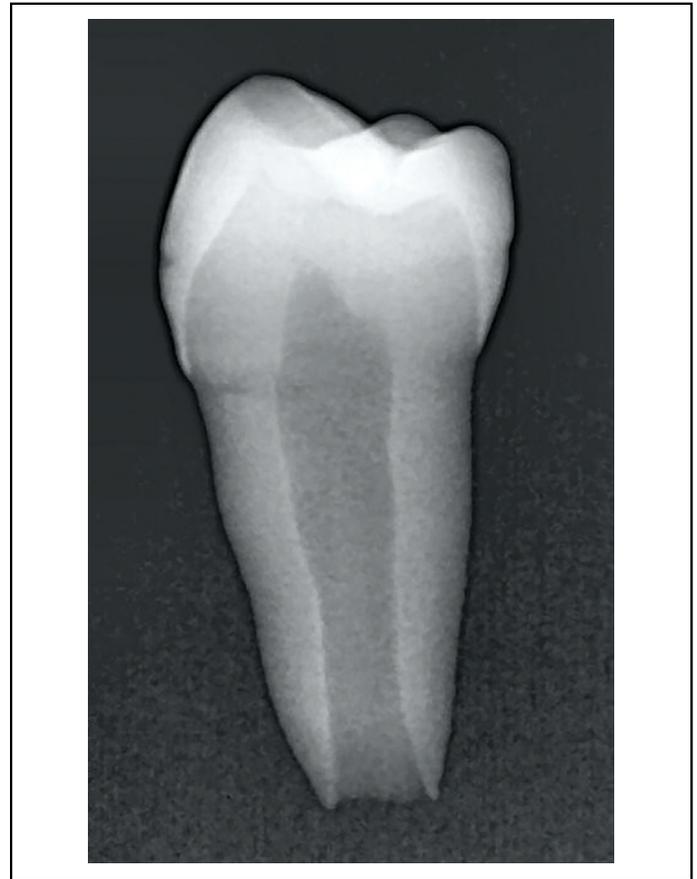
A radiograph of the extracted immature premolar
